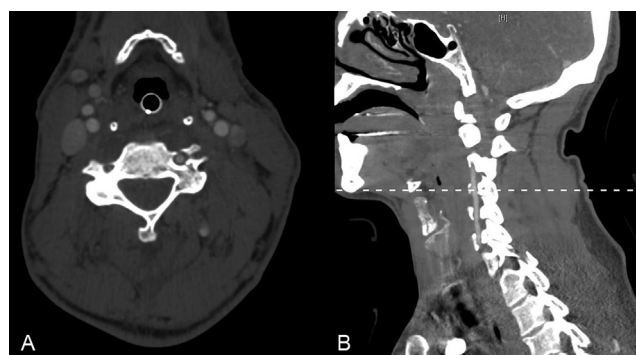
A: Axial view, computed tomography with angiography (CTA) at the C4 vertebra showing a transverse process fracture extending through the transverse foramina and into the adjacent C4 pedicle. B: CTA sagittal view demonstrating the level of the fracture (line).
